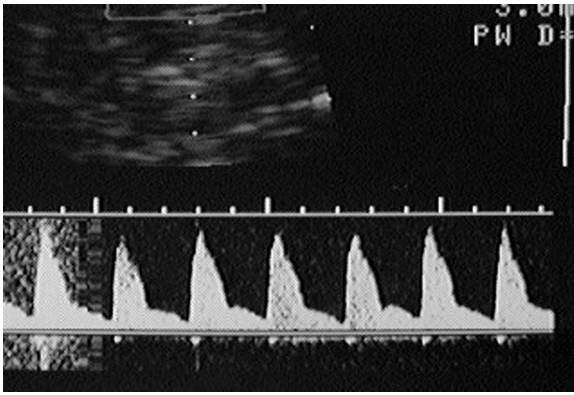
Normal (high-resistance) Doppler wave form in the middle cerebral artery
